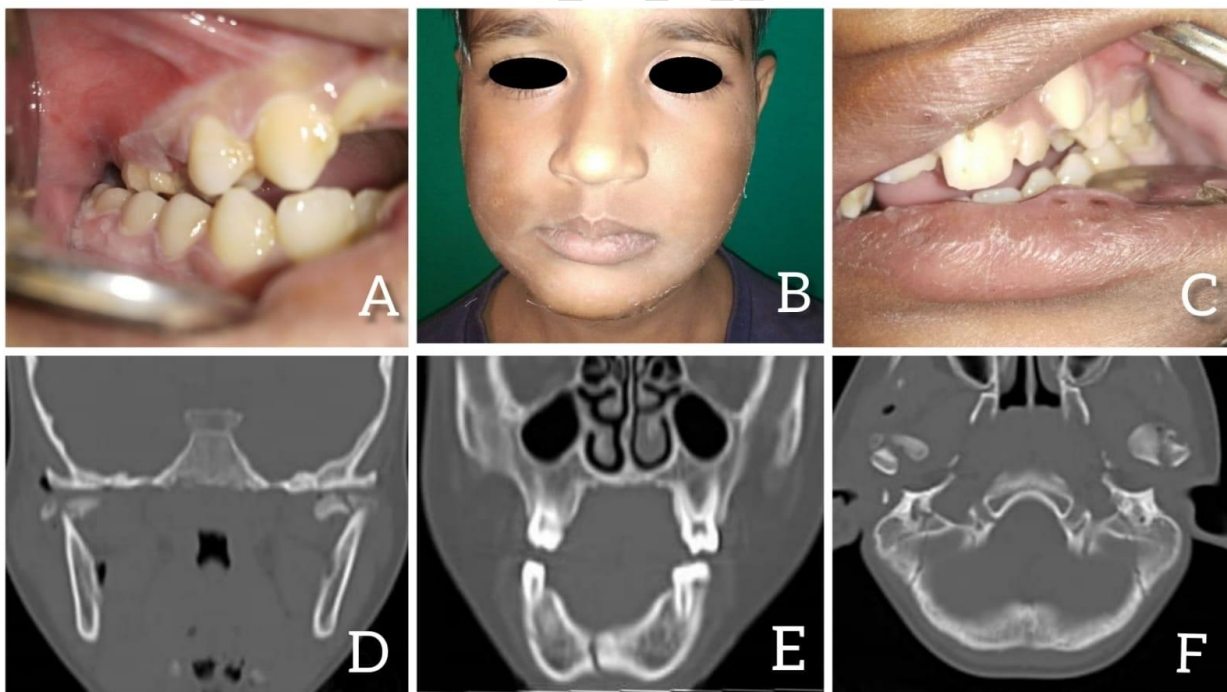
Case-Report 2, A, B, C - Pre-operative Clinical Photographs; D, E, F - Pre-operative Radiographs.
